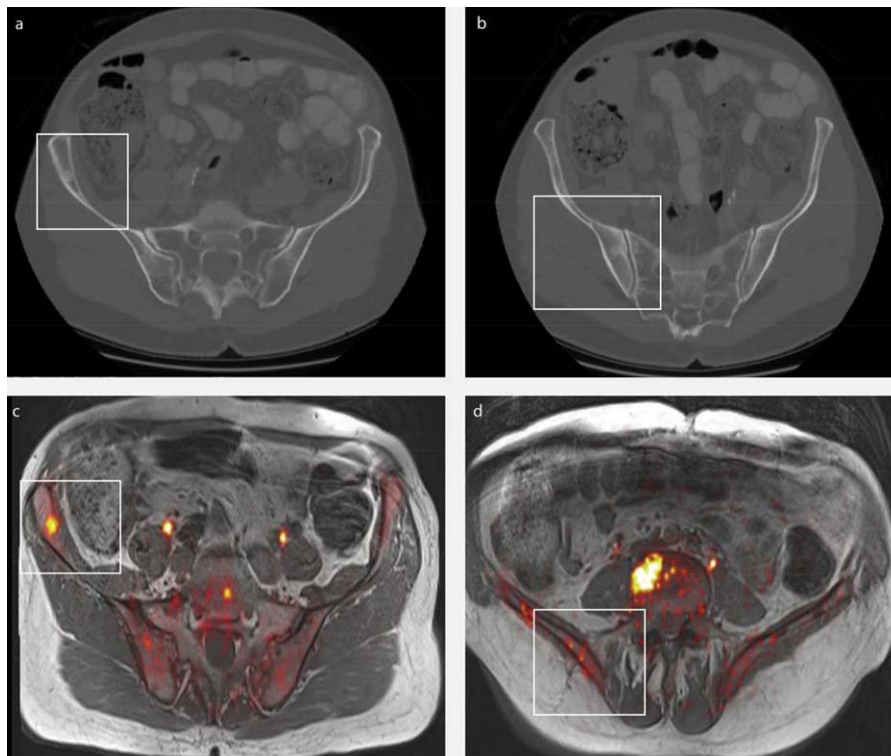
Addition of positron emission tomography (PET)-magnetic resonance imaging (MRI) to help identify which lesion to biopsy. (a and b) A 73-year-old patient with 2 bone lesions in the right iliac bone (white rectangle) shown on computed tomography. ^{18}F -sodium fluoride (^{18}F -NaF) PET-MRI clearly identified (c) tracer enrichment in the anterior lesion, (d) with no enrichment noted in the posterior lesion. The biopsy plan subsequently was changed to target the anterior lesion and the L5 vertebra.
